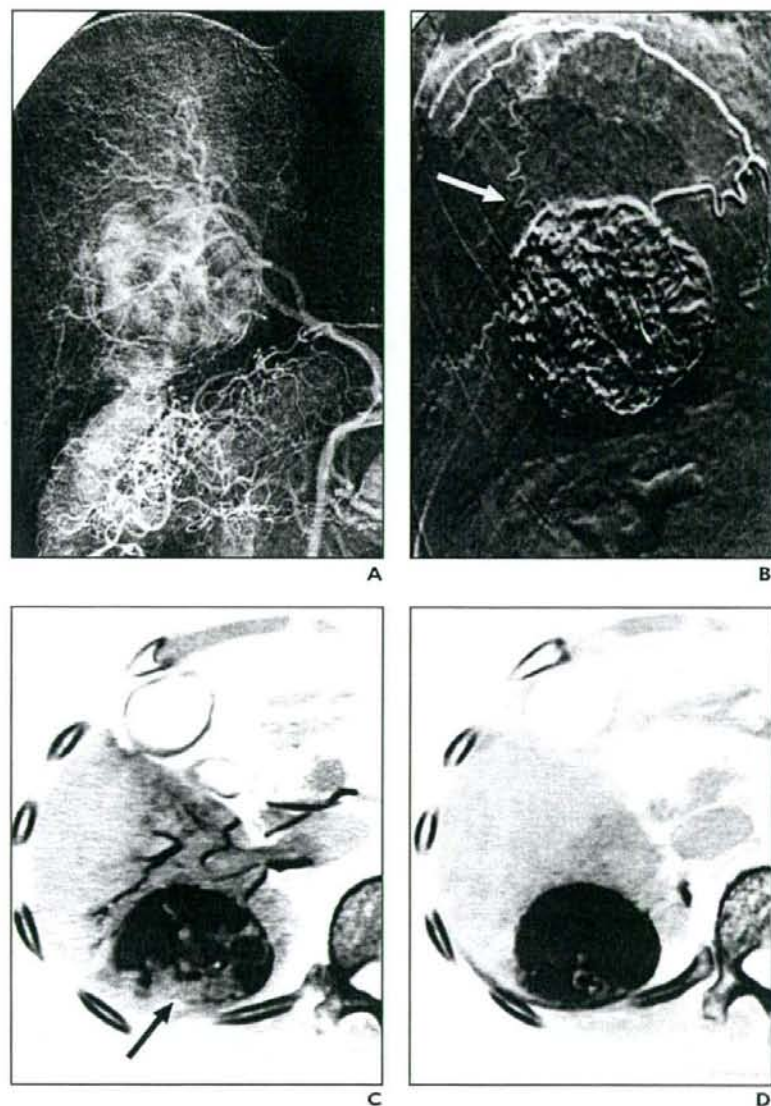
64-year-old woman who underwent transcatheter arterial chemoembolization (TACE) for hepatocellular carcinoma (HCC) with feeding from the extrahepatic artery. A and B, Angiography images show HCC was fed from branches of hepatic artery and from branch of right infraphrenic artery (arrow, B). C, CT image shows that there was part of HCC that lacked retention of lipiodol after embolization of branches of hepatic artery (arrow). D, CT image shows retention of lipiodol in entire HCC tumor after embolization of branch of right infraphrenic artery, and TACE procedure was completed.
